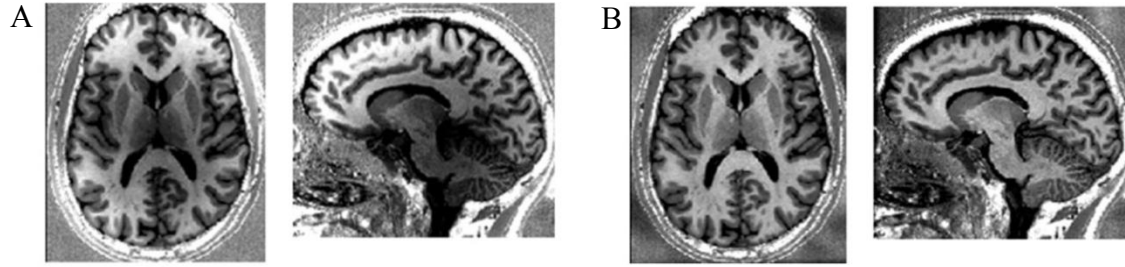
A: Effects of RF field inhomogeneities on MRI. B: MRI with corrected RF field inhomogeneities. [30]
